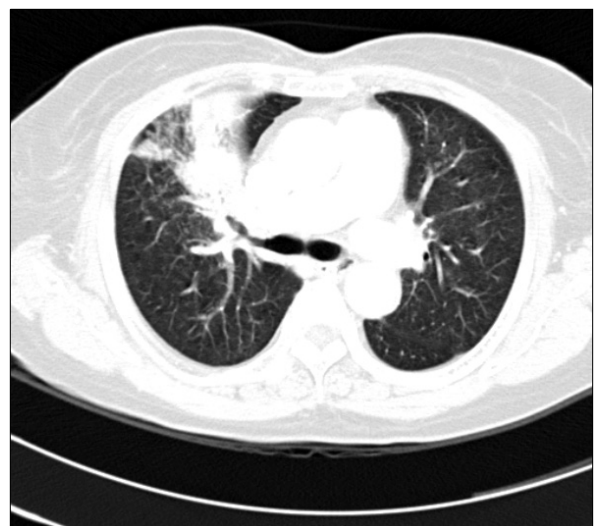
Chest computed tomography scan showed air-space consolidation and multiple centrilobular nodules in right upper and middle lobe with irregular luminal narrowing of anterior segmental bronchi of right upper lobe.
